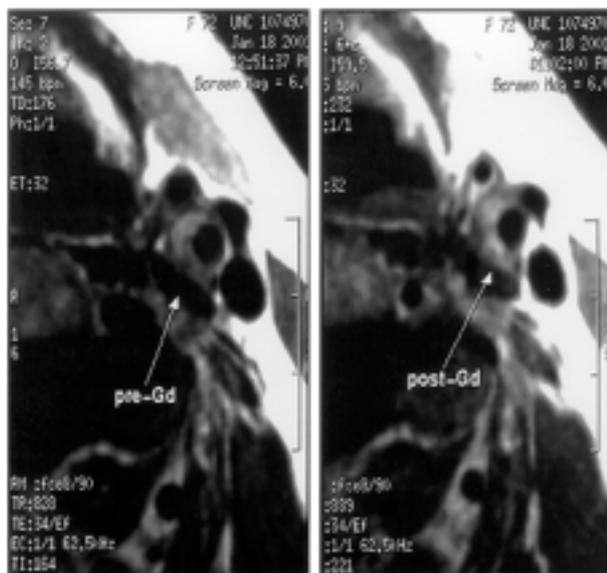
Magnetic resonance image of the left internal carotid artery: an inversion recovery-fast spin-echo sequence before (left panel) and after (right panel) gadolinium (Gd)-DTPA administration: contrast enhancement can be appreciated within carotid plaque after Gd-DTPA administration.
